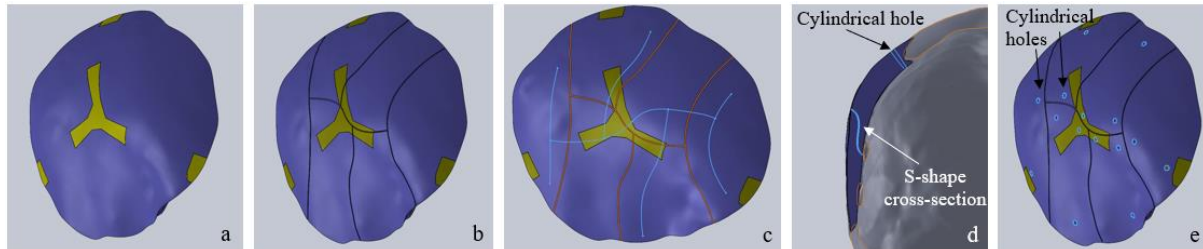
Modeling steps from the CT data to the raw implant model (a and b: splines for defect site modelling; c: Auxiliary lines for modeling the outer surface of the implant; d: raw model of the implant with skull; e and f: raw model of the implant)
